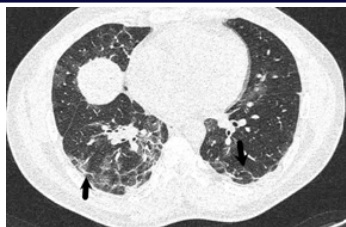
Axial nonenhanced CT lung window in 35 year old male showing subpleural linear opacities or bands (arrow) in both lower lobes.
